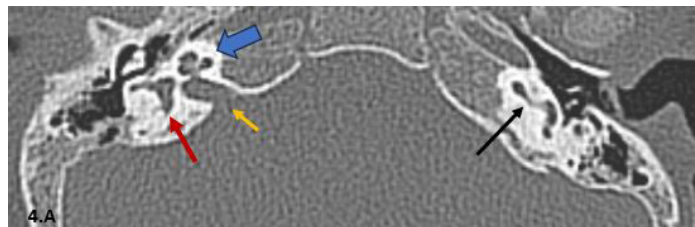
A: Axial CT view, bone window revealed normal vestibular morphology (red arrow), normal cochlear turns (blue arrow), average IAC diameter (yellow arrow), and normal basal cochlear turn (black arrow).
